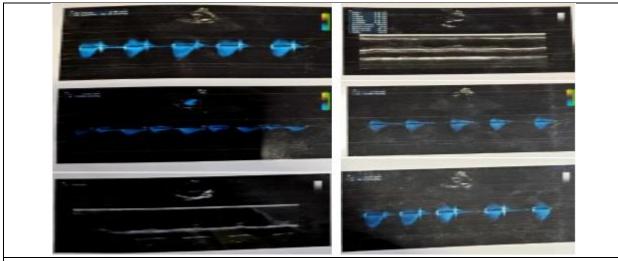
Doppler image across the pulmonary valve showing pulmonic valve PG 25.64 mmHg at 3 years of age
